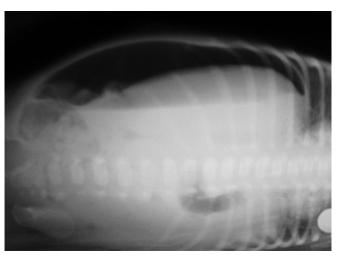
X-ray abdomen (cross table) showing presence of pneumoperitoneum
